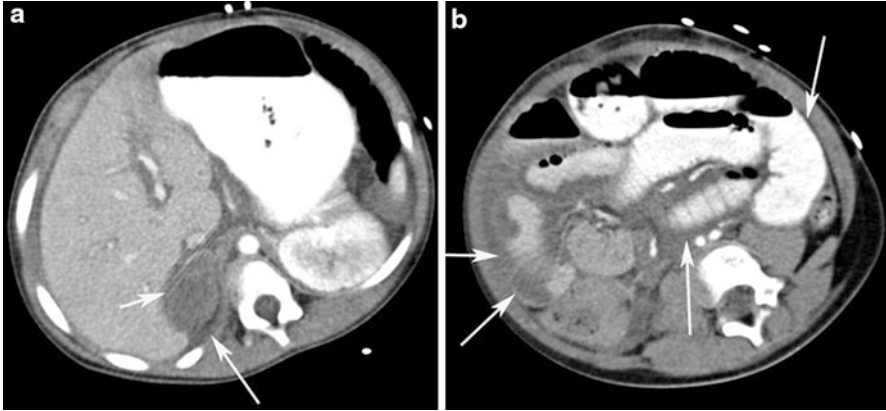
Axial CT images in a 2-year-old with non accidental trauma showing right adrenal hematoma (arrows in figure a) and small bowel wall thickening/hematoma with bowel dilatation (arrows in figure b)
